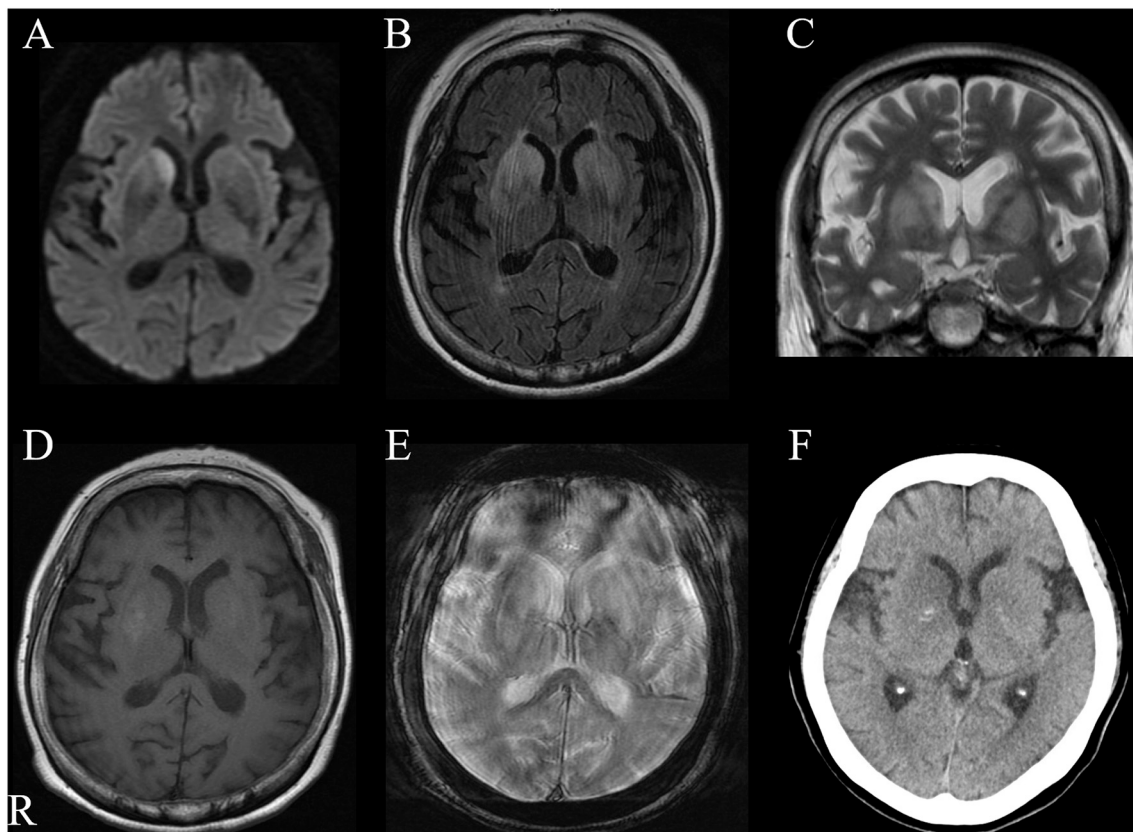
Brain magnetic resonance image (MRI) (A–E) and computed tomography (CT) (F) of the patient on day 2. (A) Diffusion-weighted image (DWI; 3.0 Tesla; b value = 1000 s/ mm^2 ; TR, 7000 ms; TE, 74.2 ms; axial) showing hyperintensity in the right caudate nucleus. (B) Fluid-attenuated inversion recovery image (FLAIR; 3.0 Tesla; TR, 10,000 ms; TE, 118.7 ms; axial) showing a hyperintensity lesion in the bilateral basal ganglia. (C) T2-weighted image (T2-WI; 3.0 Tesla; TR, 4841 ms; TE, 87.6 ms; coronal) showing a hyperintensity lesion in the bilateral basal ganglia. (D) T1-weighted image (T1-WI; 3.0 Tesla; TR, 2483 ms; TE, 18.9 ms; axial) showing calcification of the right basal ganglia. (E) T2 star-weighted image (T2 star-WI; 3.0 Tesla; TR, 550 ms; TE, 18.0 ms; axial) showing no hemorrhagic lesions. (F) Brain CT (axial) showing low density in the right caudate nucleus and no hemorrhagic lesions. Abbreviations: CT: Computed tomography, DWI: diffusion-weighted imaging, FLAIR: Fluid-attenuated inversion recovery imaging, MRI: Magnetic resonance imaging, WI: weighted image.
